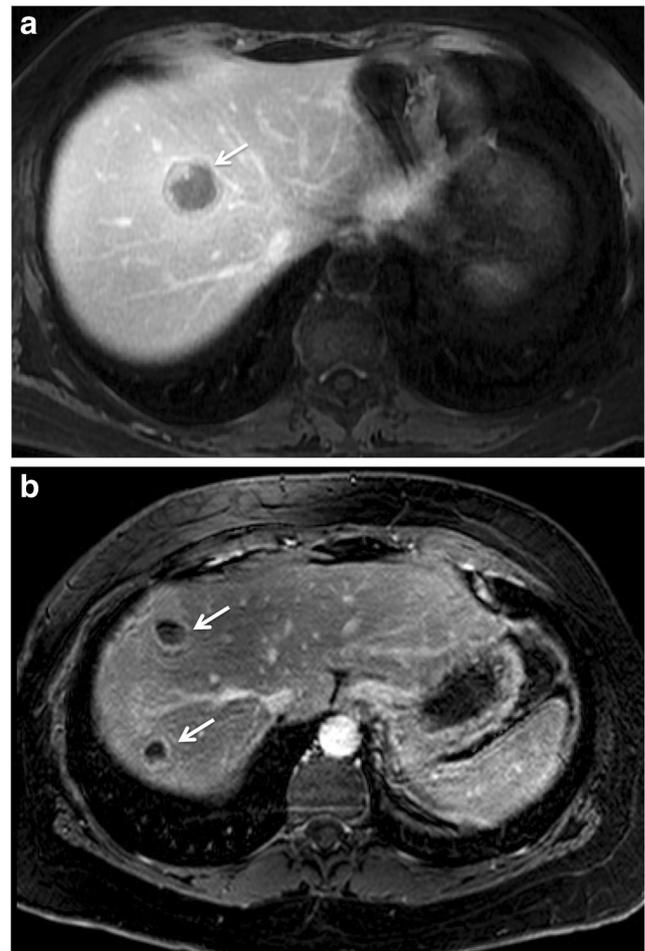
Abdominal MR image demonstrating weak TTE in colorectal liver metastases in (a) a 56-year-old female and (b) a 43-year-old female
